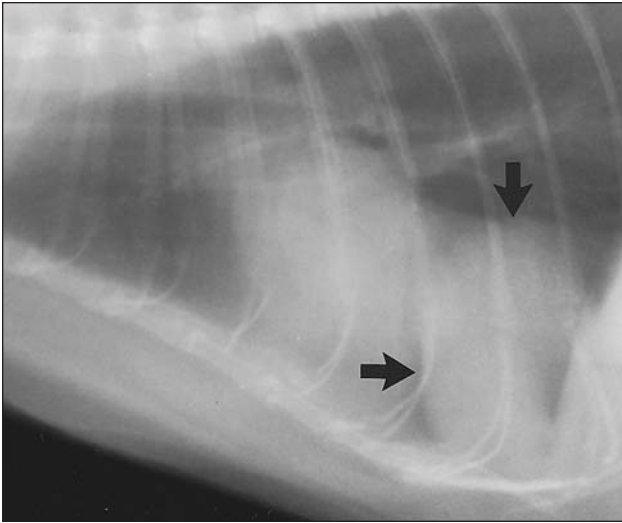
Same radiographic views as in Figure 1. A circumscribed 3.5-cm soft-tissue mass (arrows) is evident in the ventral region of the thoracic cavity between the heart and the right crus of the diaphragm.
